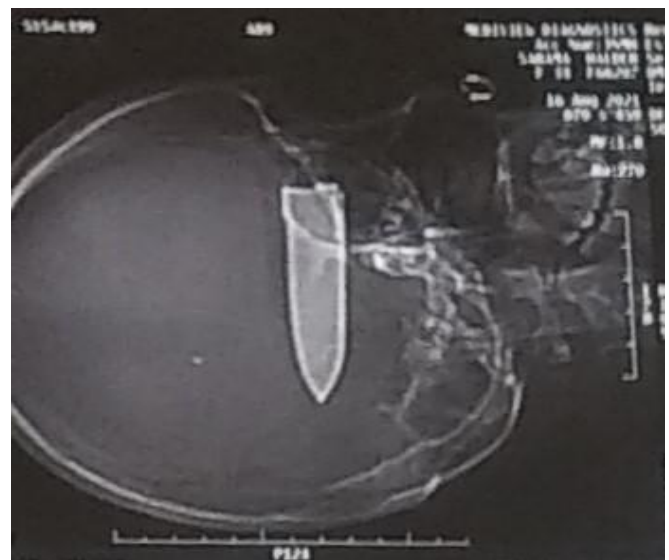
Plain Pre OP CT Scan Brain (TOMOGRAM) Radio Opaque Object Shape of Knife penetrating the left temporal region and crossing the mid sagittal plane (Fig 2)
